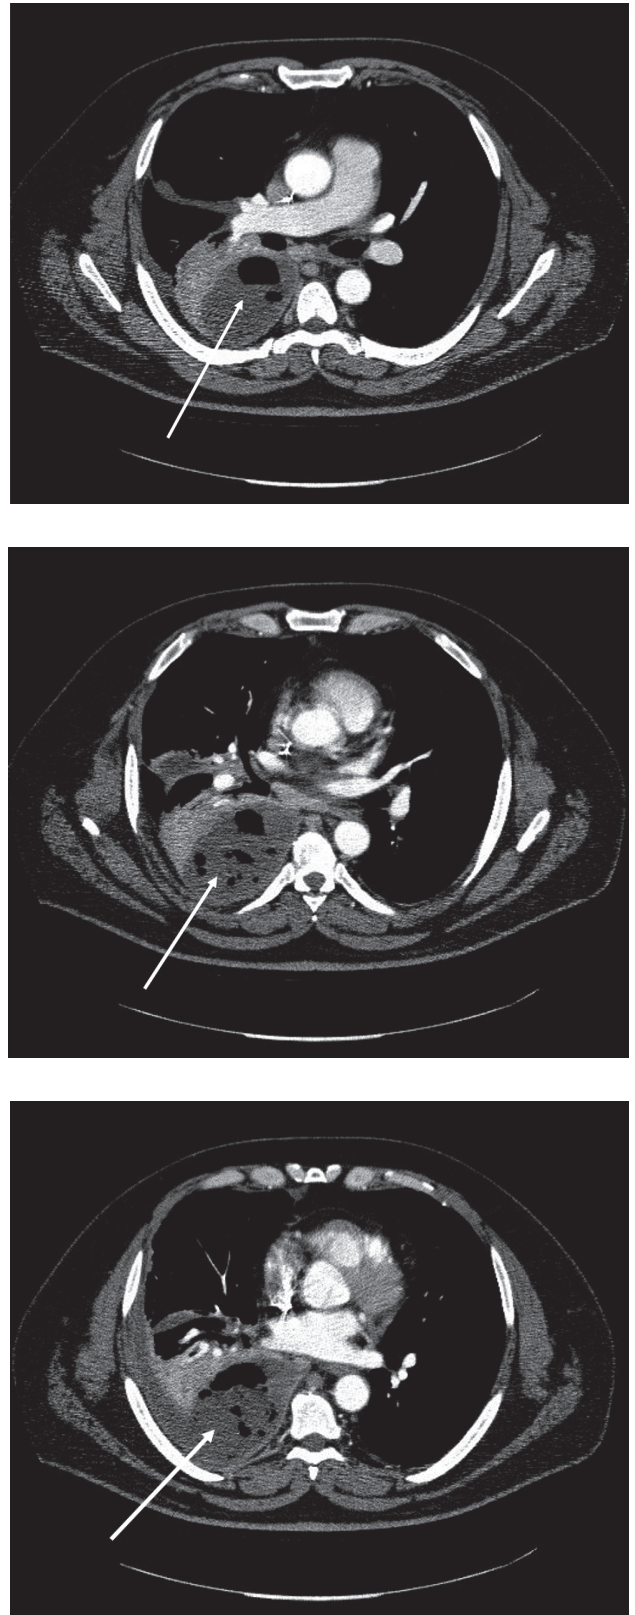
CT scan on admission: encapsulated collection of material with air bubbles in the right pleural cavity
